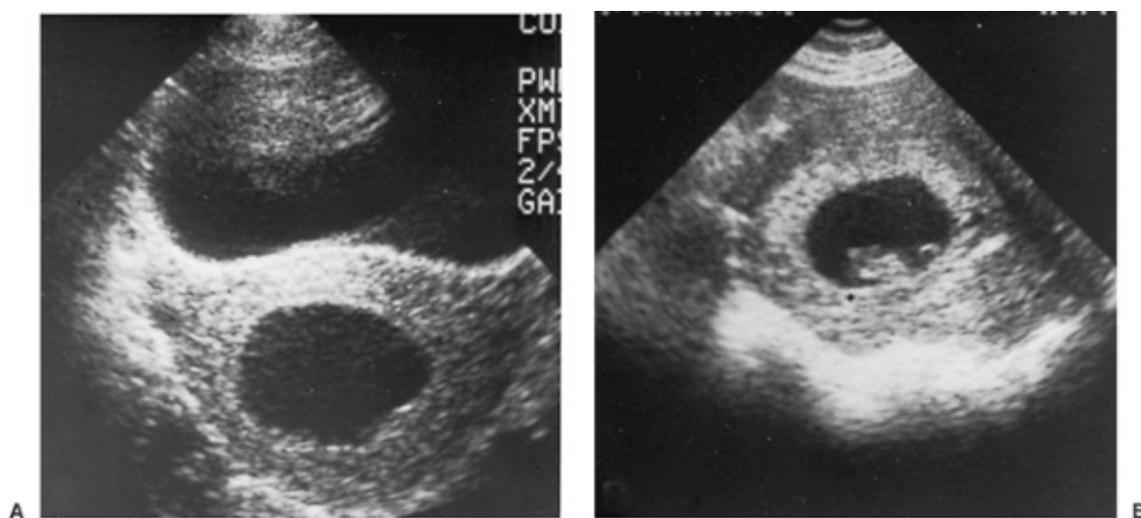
Ultrasonic comparison of (A) an anembryonic pregnancy with no fetal tissue that is destined to abort with (B) a normal gestational sac with a transonic area, echogenic rim, and fetal pole.
